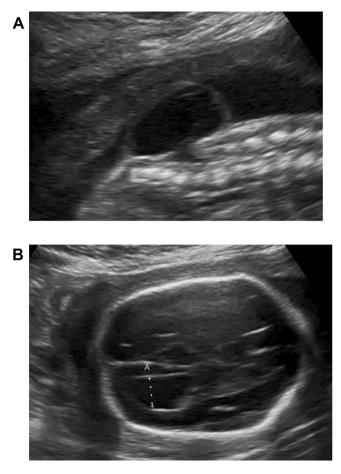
A. Ultrasound image at 23 weeks gestation showing fetal lumbosacral Myelomeningocele. B. Ultrasound image at 23 weeks gestation showing fetal lateral ventriculomegaly.
